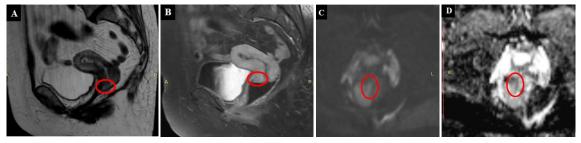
Pelvic MRI Examination of Case 5
